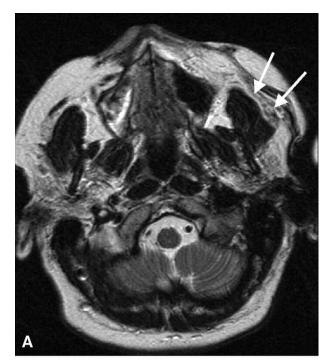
MRI appearance of microneurovascular muscle flap in a 54-year-old woman with left-sided facial paralysis after cranial base fracture. Free muscle transfer with the latissimus dorsi was done 10 years before MRI. This flap has a fatty appearance (grade 2 in present study) and patient's mimic function is quite good (mild dysfunction). (A) In an axial T2-weighted MR image and (B) in an oblique coronal T1-weighted MR image the free muscle flap is indicated with a white arrow.
